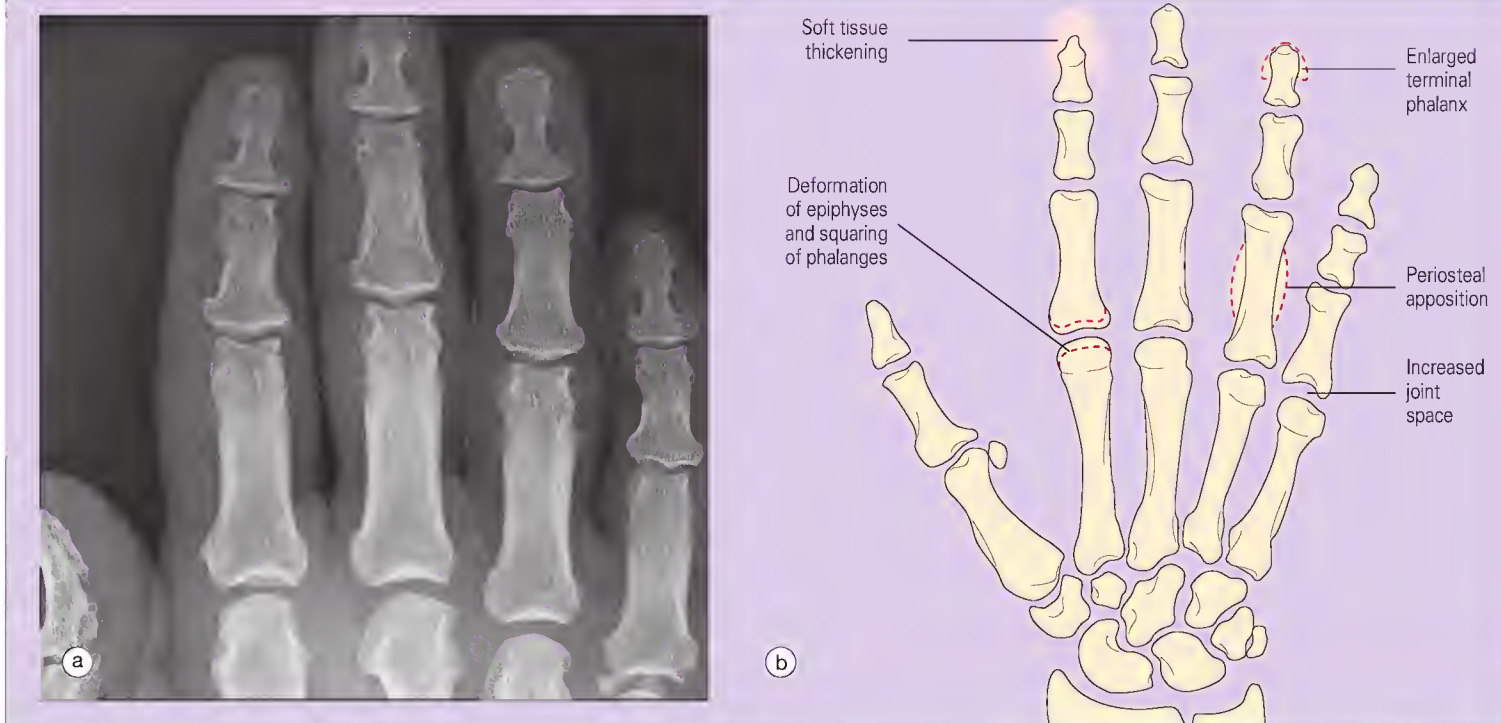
(a) Apart from the soft tissue thickening of the hand, this radiograph also shows the increased joint space and enlargement and tufting of the terminal phalanges. (b) Examination of the hand is important for the diagnosis of acromegaly.
